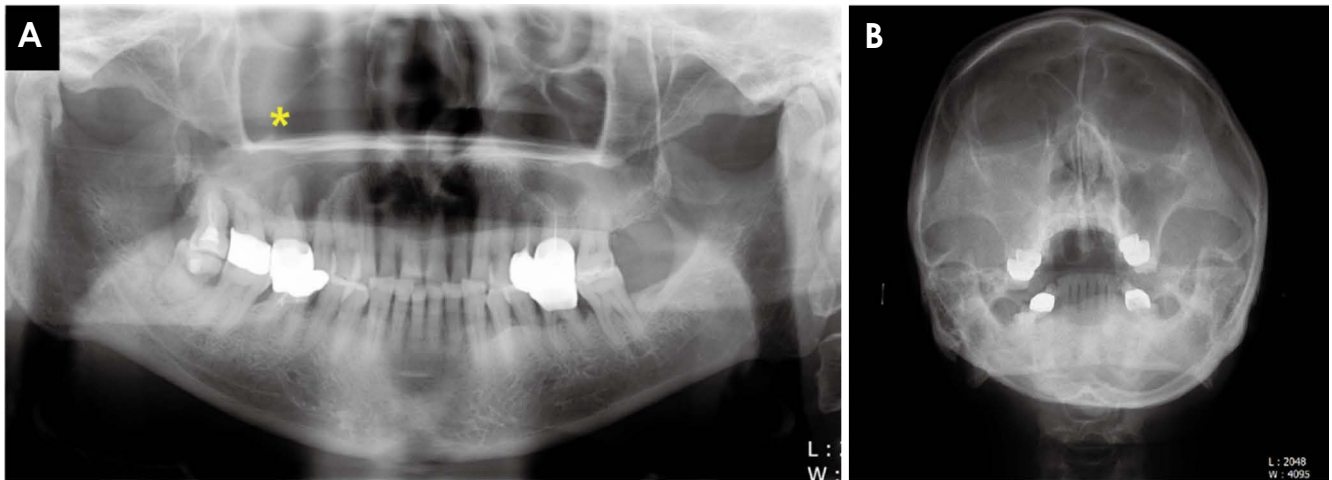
A. A panoramic radiograph shows a well-defined expansile cystic lesion (asterisk) in the right maxillary sinus. Downward displacement of the maxillary sinus floor and upward displacement of the orbital floor are observed. B. A Waters' radiograph reveals opacification of the entire right maxillary sinus.
